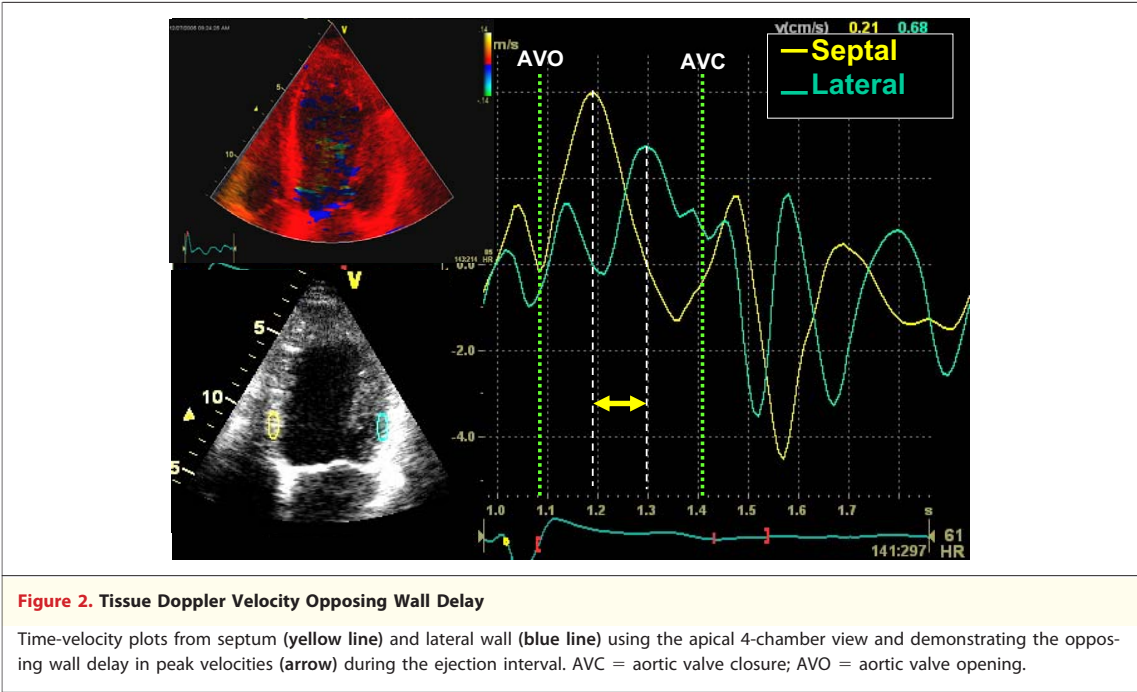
Tissue Doppler Velocity Opposing Wall Delay
